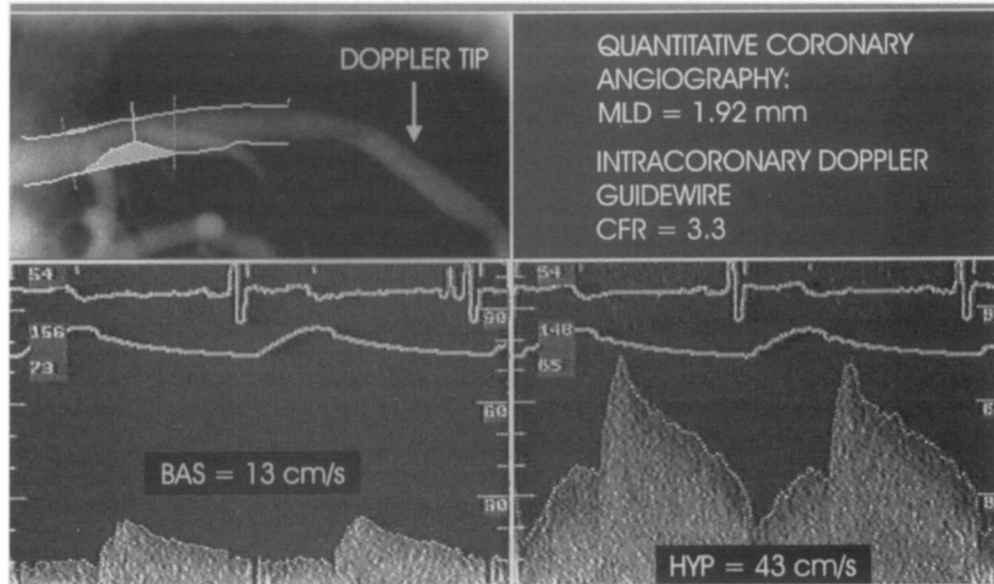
Quantitative coronary angiography (left upper panel) of intermediate lesion in proximal segment of left anterior descending coronary artery. A 42% diameter stenosis was found but angiographic analysis was limited by sidebranches and overlapping vessels in all projections. Assessment of coronary flow velocity with Doppler guide wire distal to stenosis revealed normal coronary flow reserve of 3.3, calculated as ratio between average peak flow velocity at baseline (left lower panel) and hyperemia (right lower panel). Arrowhead indicates position of Doppler tip during flow velocity measurement. *BAS*, Baseline; *CFR*, coronary flow reserve; *HYP*, hyperemia; *MLD*, minimal luminal diameter.
